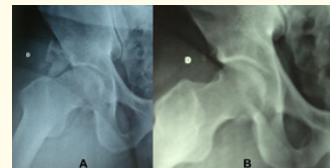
Patient with cam FAI associated with subspine impingement in right hip. (A) Preoperative radiograph of right hip in Dunn view at 45° with an alpha angle of 89° and (B) postoperative radiograph in the same view after femoral osteoplasty and treatment of subspine impingement via the anterior approach at an alpha angle of 45°.
